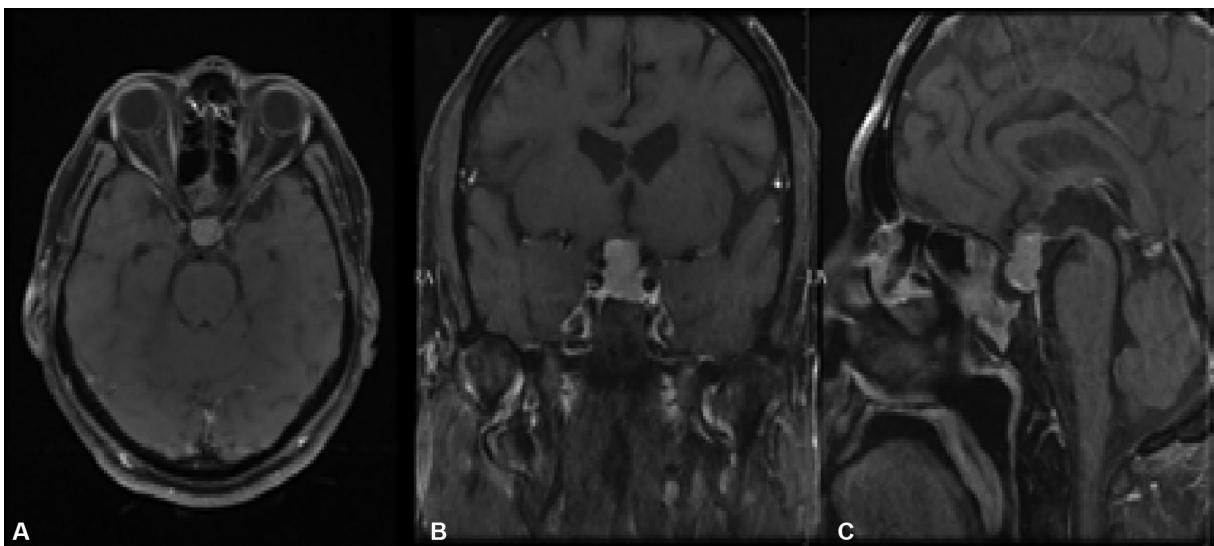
Magnetic resonance imaging (MRI) brain contrast in April 2016 recurrence of pituitary macroadenoma and hyperintensity in sphenoid sinus suggestive of sinusitis.
